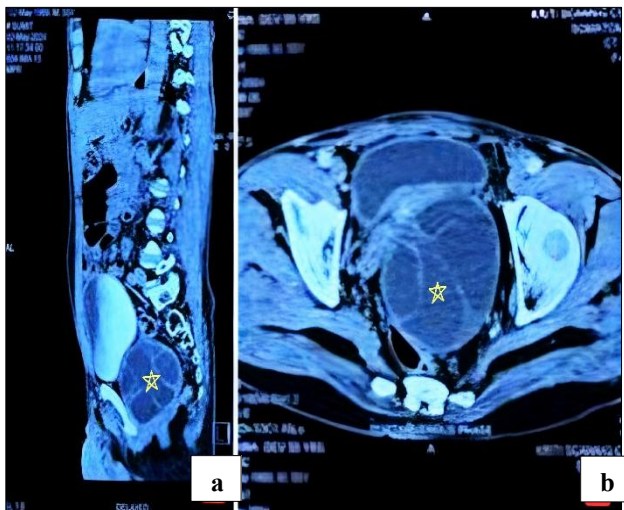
Computed tomography (CT) images demonstrating a large, multiloculated seminal vesicle cyst (yellow asterisk), (a) sagittal plane view showing the superior-inferior extent of the cystic mass, and (b) axial plane view highlighting the multiloculation and displacement of adjacent structures.
